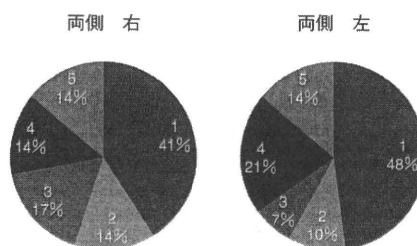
Types of lymphoscintigraphic images in the bilateral lymphedema
